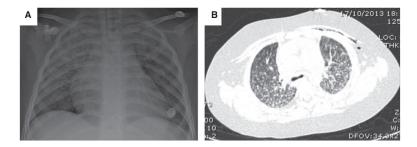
Infiltration of both lungs by multiple micronodules shown in chest X-ray (A) and thoracic computed tomography (B) in a 3 years old child with miliary TB.
